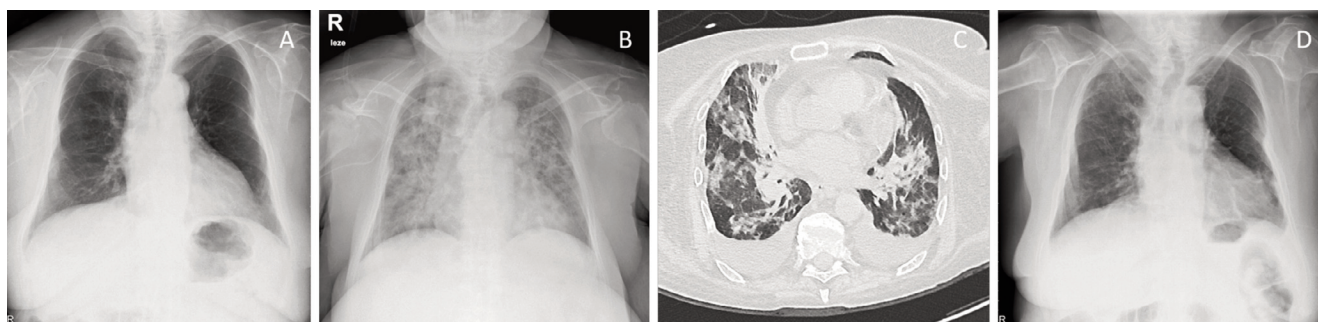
Chest X-ray and computed tomography (CT): radiograph before tocilizumab infusion (A); radiograph 1 day after tocilizumab (B); CT 3 days after tocilizumab (C); radiograph 10 days after tocilizumab (D).
